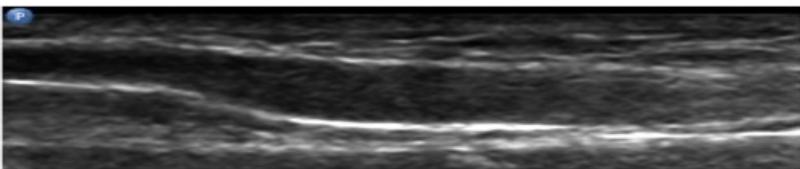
Figure Ultrasound view of the radial artery.
